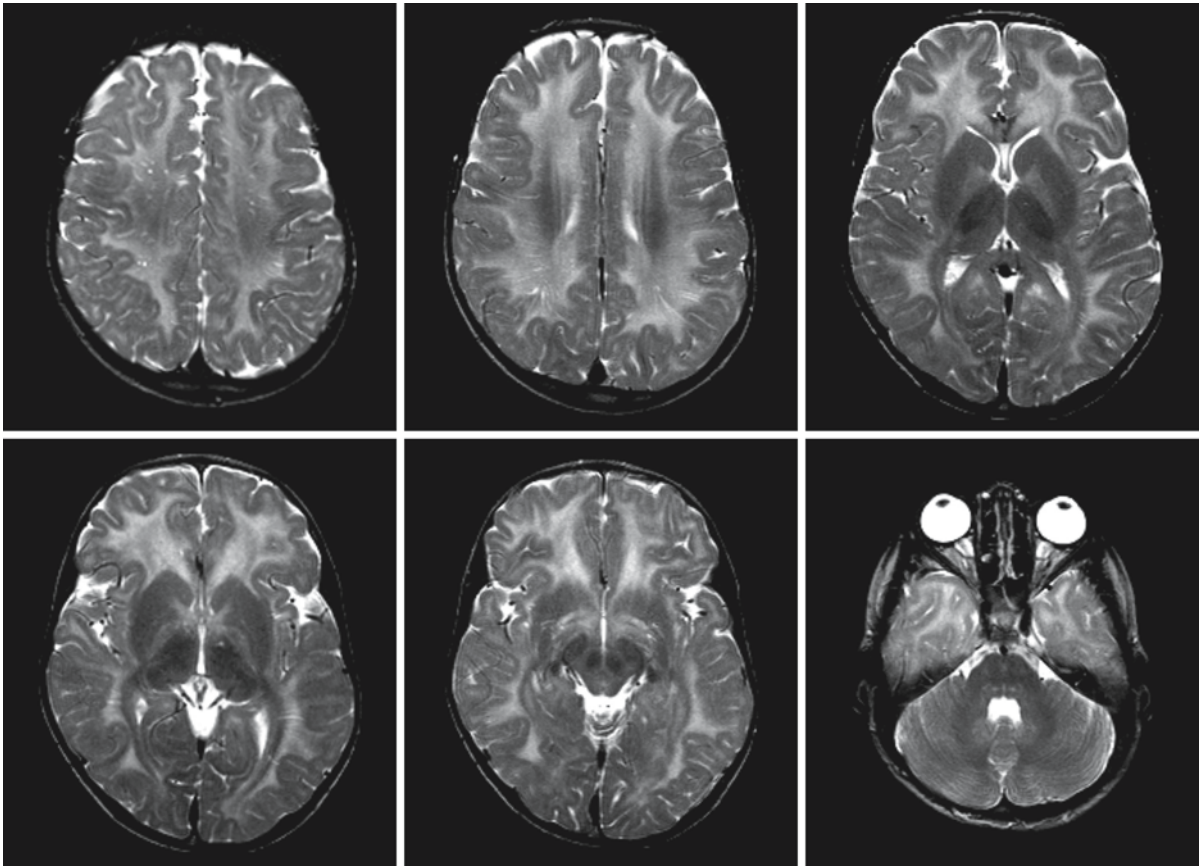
Boy with methylenetetrahydrofolate reductase deficiency at the age of 5 years. The T_2 -weighted MR images show that the cerebral white matter has an elevated signal throughout. The corpus callosum also has a slightly abnormal signal.
